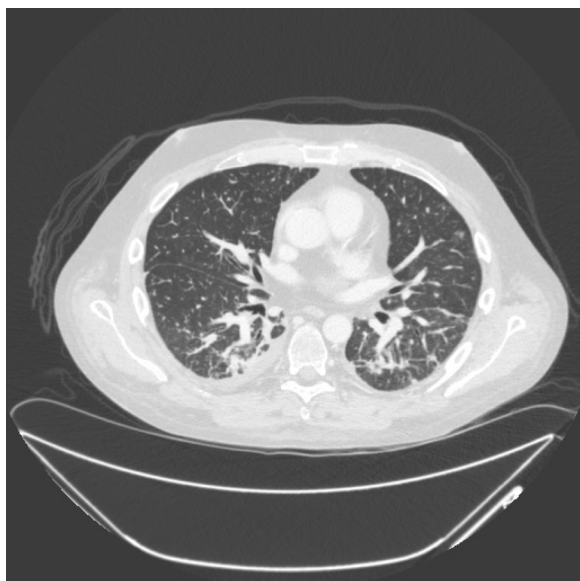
CT chest on hospital day 4, showing multiple pulmonary nodules and tree-in-bud opacities.
